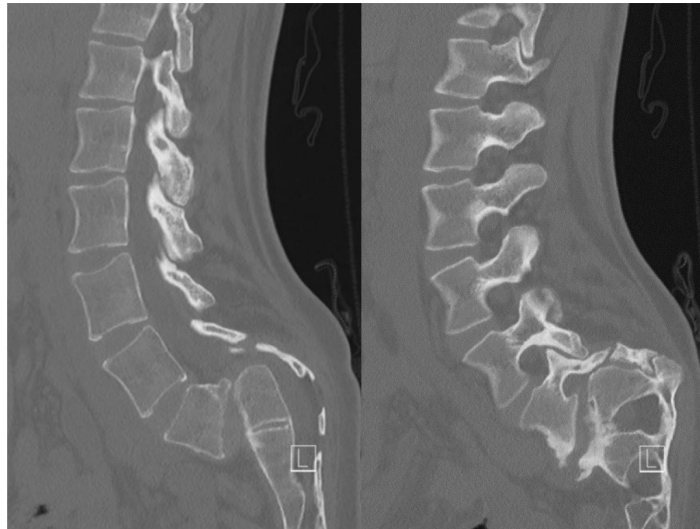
Pre-operative sagittal CT.
